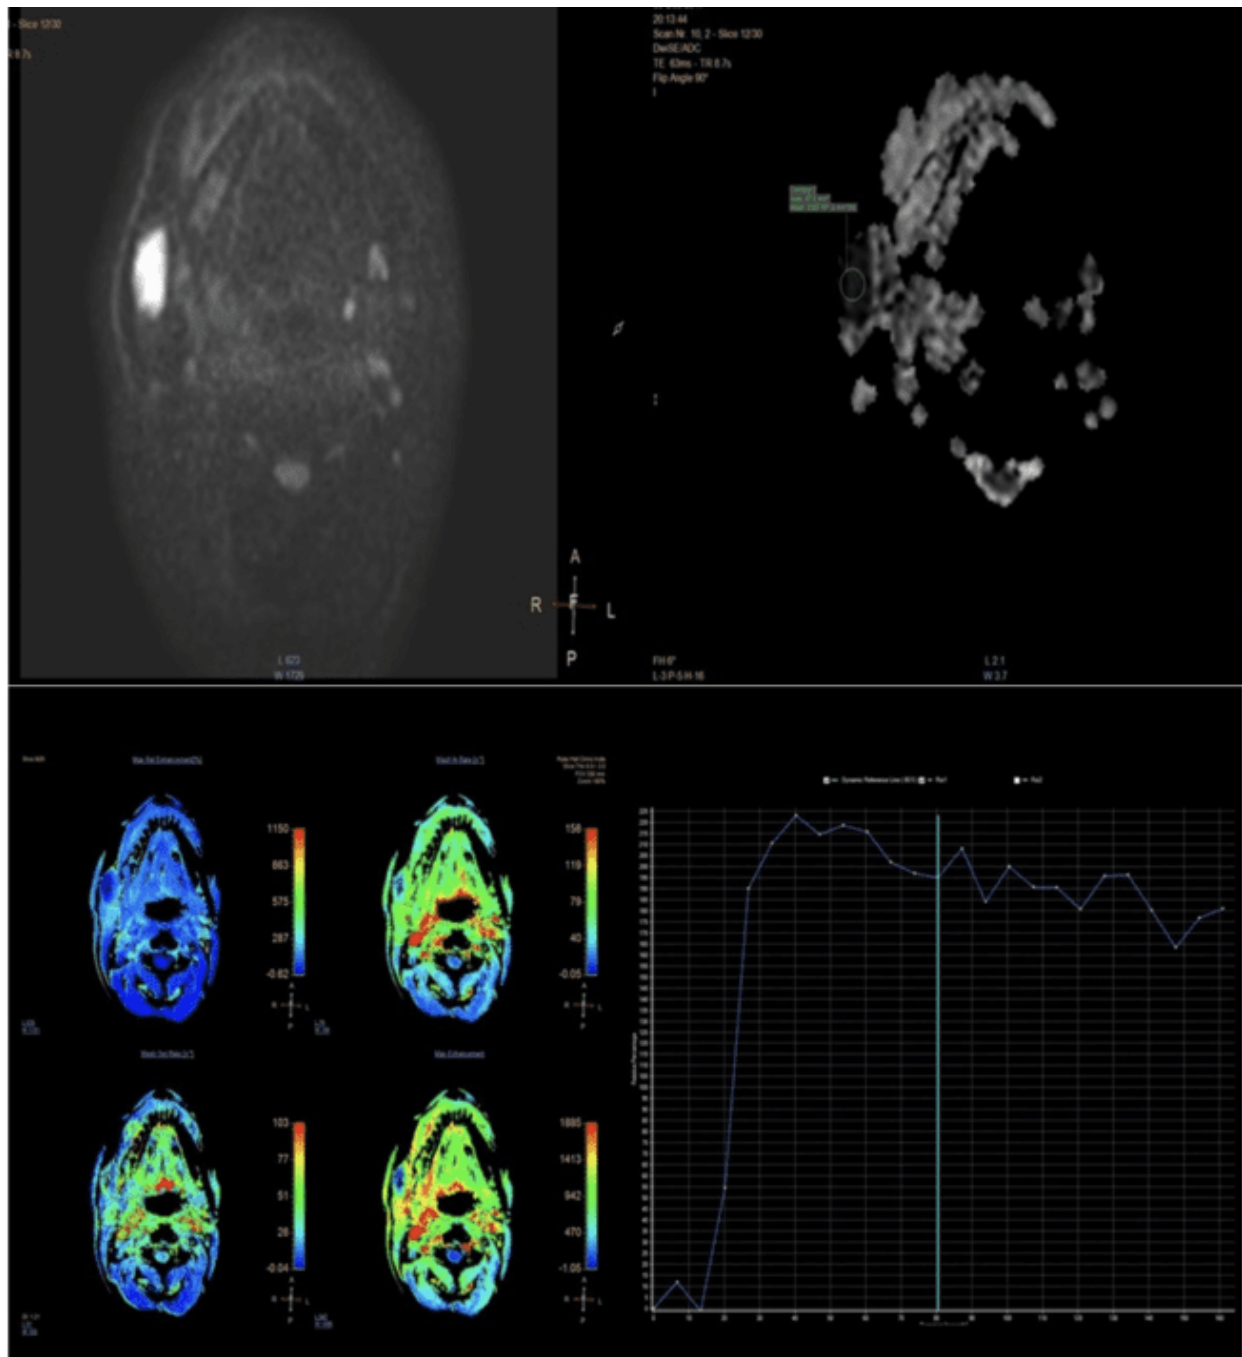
Case of Parotid adenoma. The upper row shows diffusion restriction on diffusion-weighted images ( $b=800$  mm<sup>2</sup>/s ), with the corresponding area showing low values for the ADC image. The ADC value of the lesion was measured as  $1.1 \times 10^{-3}$  mm<sup>2</sup>/s. The lower row DCE-MRI shows Type A TIC
